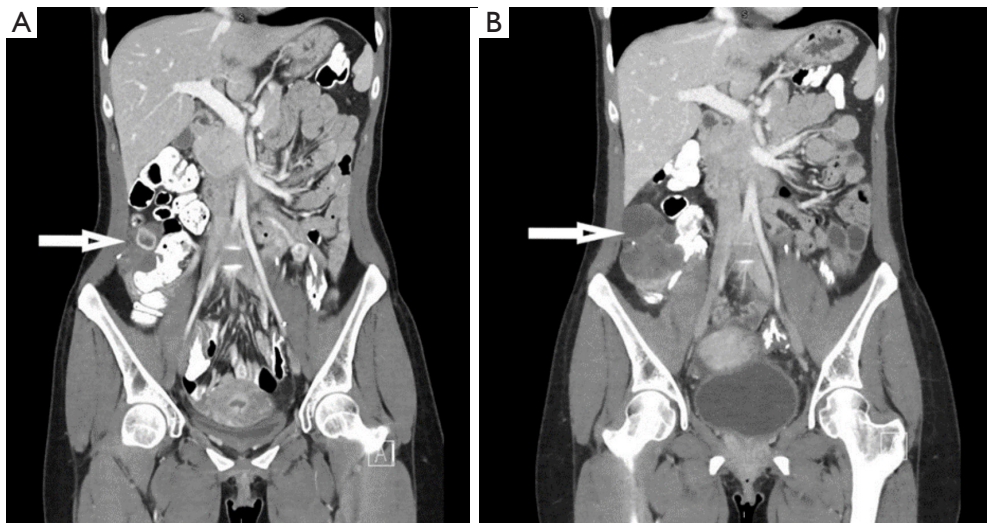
Metastatic progression in the transposed ovary of a 29-year-old female with colorectal adenocarcinoma primary. CT scans of the abdomen and pelvis, 2 months progression. (A) Status post left oophorectomy, post interval transposition of the right ovary into the right lower quadrant with adjacent surgical clips. The ovary is situated between the anterior abdominal wall and the ascending colon. The right ovary appears enlarged, measuring 5.2×2.5 cm², previously normal in size. (B) The right ovary is enlarged, measuring 7.9×3.9 cm², and contains multiple cysts. Differential included ovarian torsion and metastasis. Subsequent oophorectomy and pathological analysis confirmed metastasis. CT, computerized tomography.
